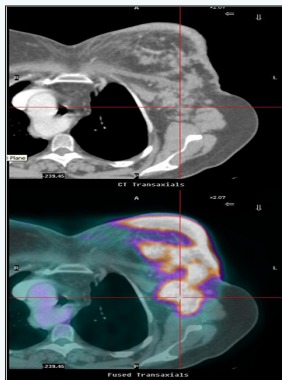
A PET-CT was performed, and no systemic disease was found:
